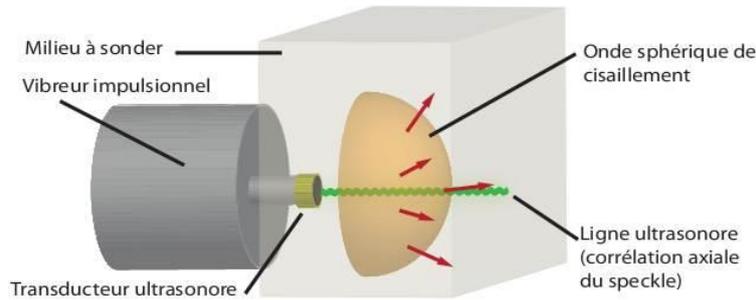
The vibrator gives a low frequency touch (about 50 Hz) to the sample, generating a compressional and a shear wave. The ultrasound probe (which is placed over the vibrator) permits monitoring the shear wave propagation within the medium by using speckle axial correlation more than 1000 times/s. Therefore, the shear wave velocity and the material's Young's modulus can be retrieved [31].
